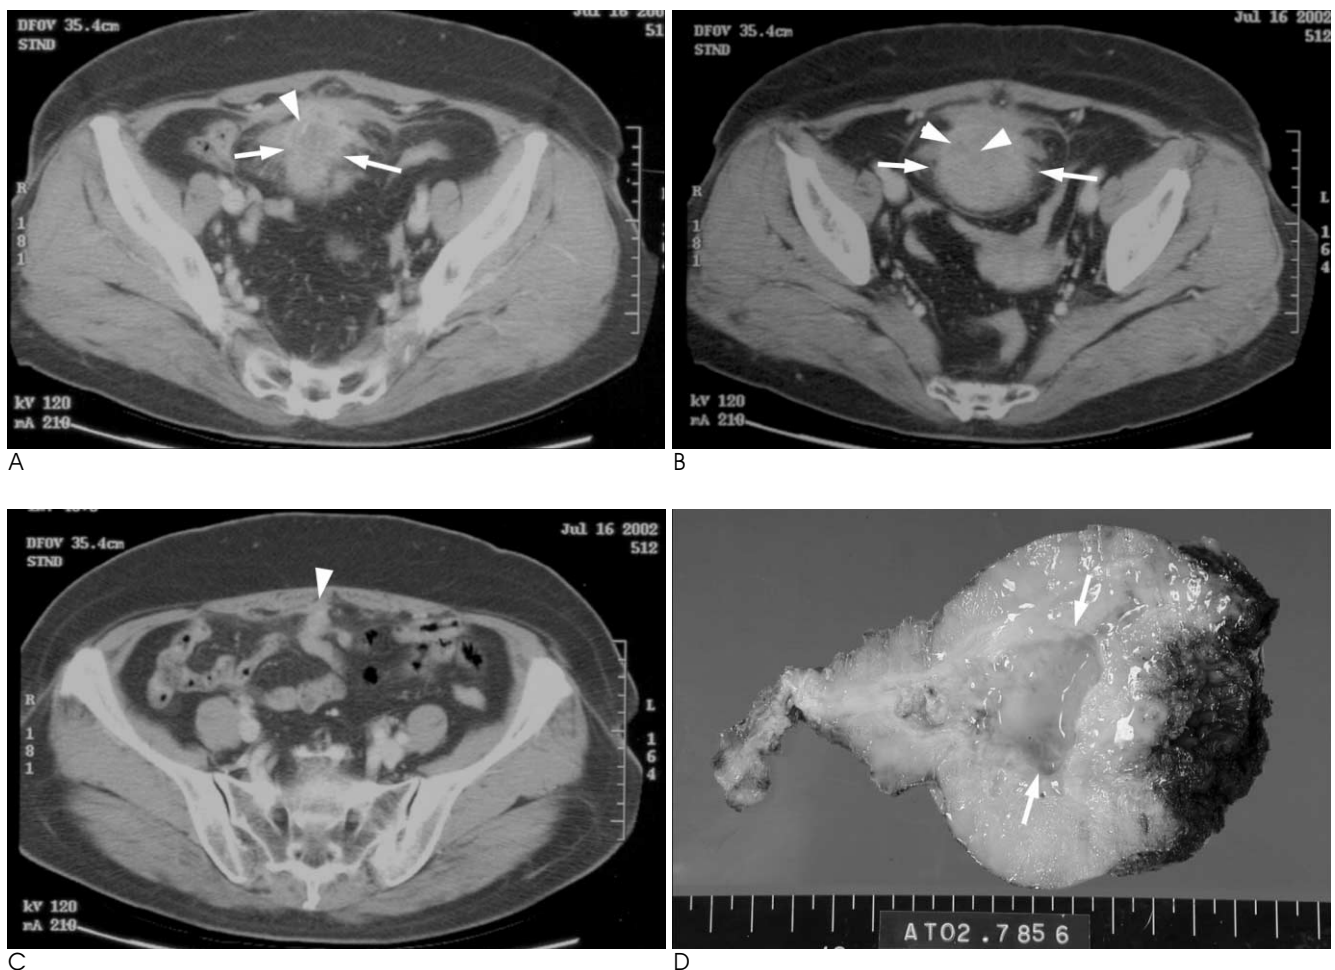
A 70-year-old woman with urachal actinomycosis. Contrast-enhanced abdominal and pelvic CT (A-C) show a 6 × 5 cm, densely enhancing infiltrative mass (arrows) with internal, low attenuating necrotic foci (arrowheads) in the midline of the lower abdomen (A, B). It shows diffuse mural thickening and dense enhancement with infiltrative borders contiguous to the bladder. At the upper portion of the mass, a thickened median umbilical ligament (arrowhead) is shown (C). Gross examination of the mass on multiple sections revealed an abscess cavity (arrows) containing yellowish pus (D).
